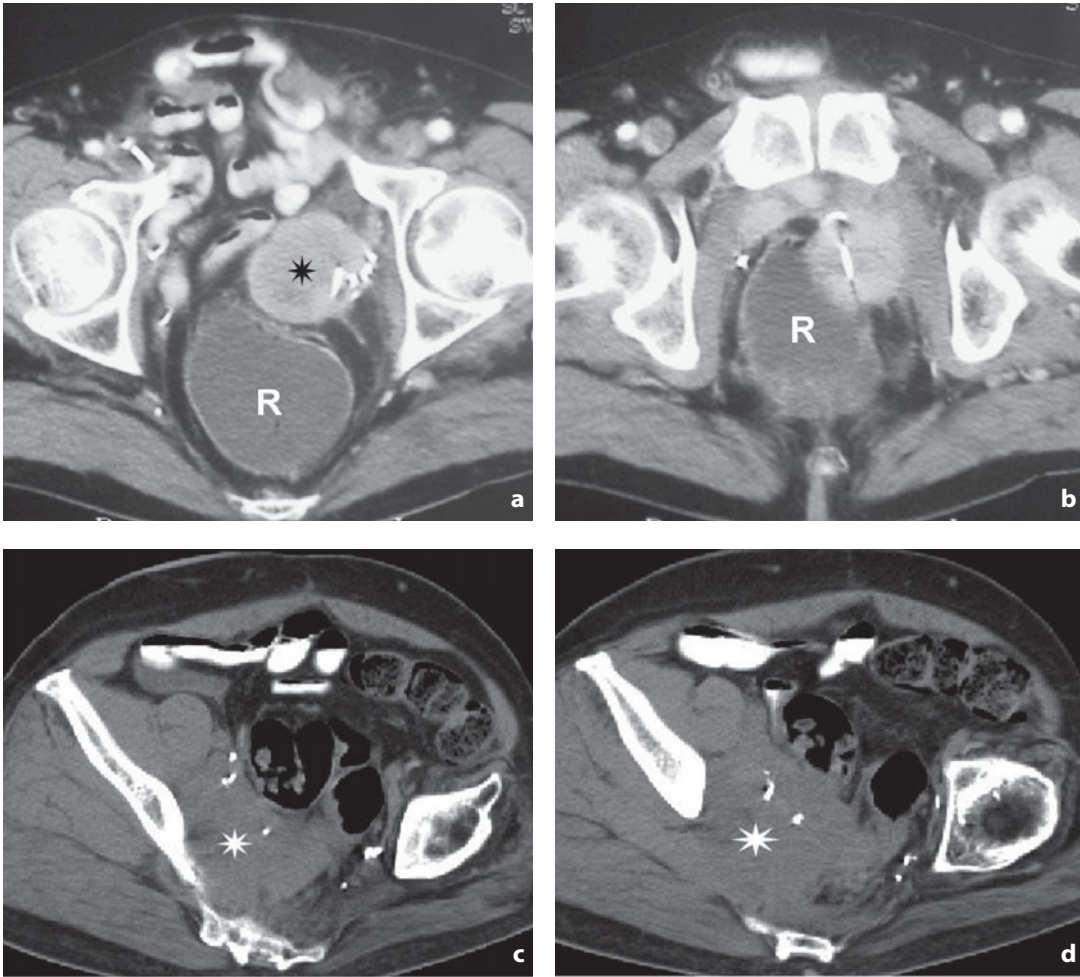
Computed tomography. Local recurrence after radical cystectomy. a,b Round nodule (*asterisk*) corresponding, with a metal clip of a prior surgical procedure. c,d Different patient. Extensive recurrence (*asterisk*) involving the right hemipelvis. *R*, rectum
